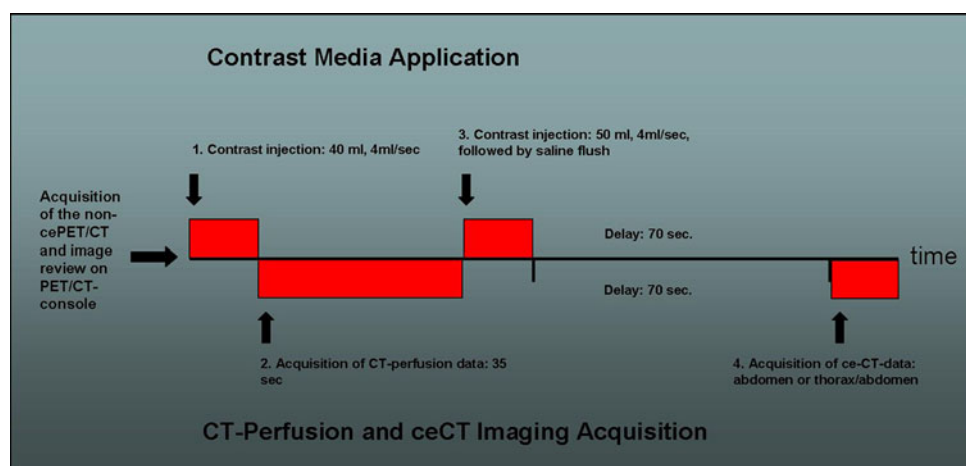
The course of the examination protocol. The non-enhanced PET/CT is acquired first. After review of the images, the position of the target lesion was defined and the perfusion volume was adjusted accordingly. Directly after the acquisition of the perfusion data, the routine ce-CT was conducted.
